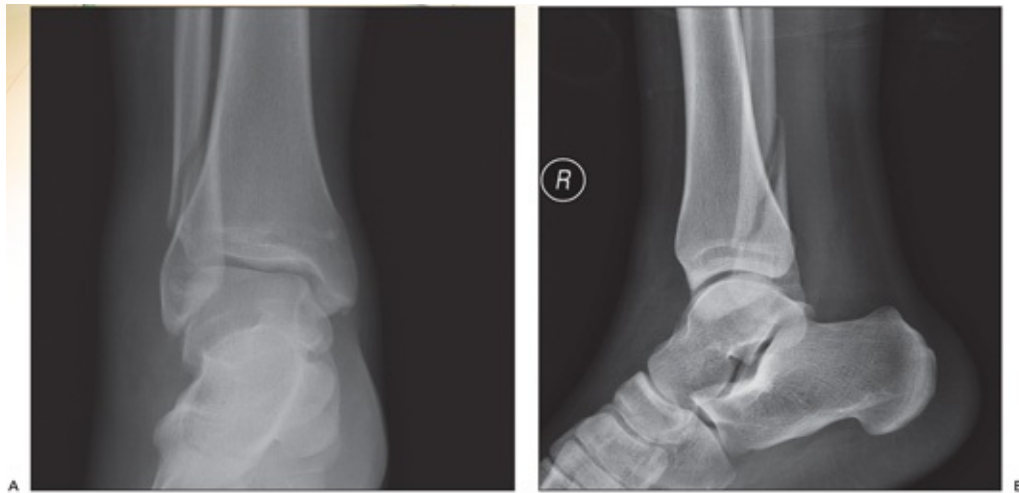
Weber B distal fibula fracture. Anteroposterior (A) and lateral (B) radiographs.
